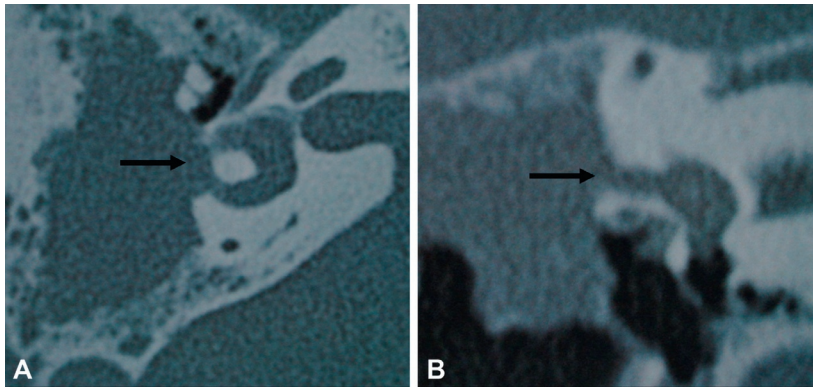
Horizontal canal fistula due to cholesteatoma. Axial (A) and coronal (B) computed tomography scan demonstrates a fistula of the horizontal semicircular canal (arrow) due to an extensive cholesteatoma of the middle ear.
